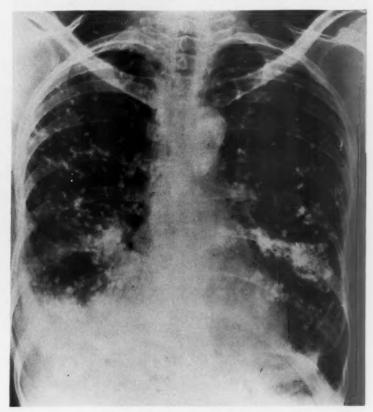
Chest x-ray, May 3, 1958.
